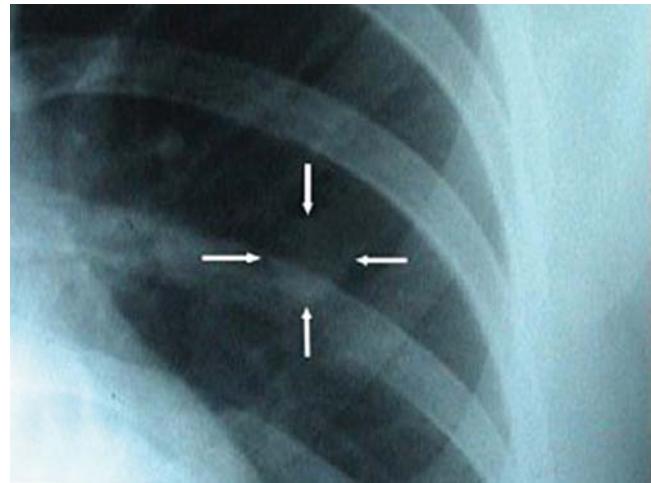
Spot radiograph showing a coin lesion marked with arrows (Courtesy of Dr. Ufuk Cagirisi, Ege University Medical Faculty, Izmir, Turkey). With permission from Interact Cardiovasc Thorac Surg, see chapter references for complete citation.
